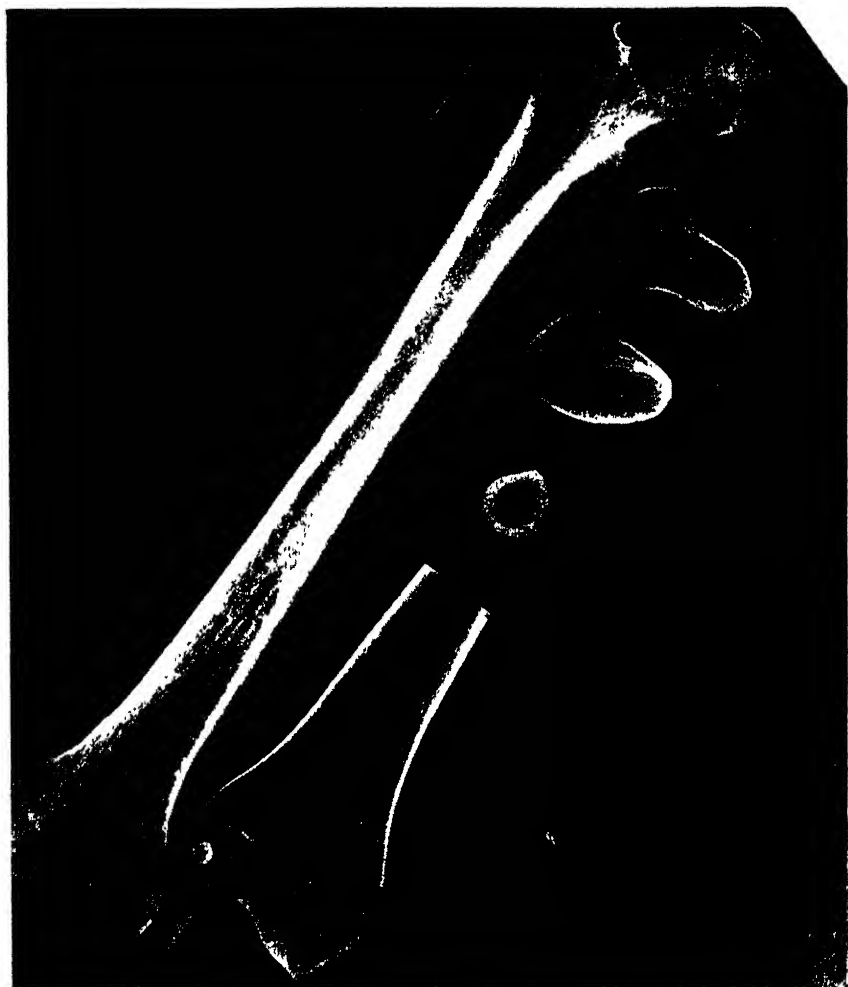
RADIOGRAPHIC APPEARANCES (NEGATIVE) OF A LONG BONE, AND OF SECTIONS SHEWING SPONGY BONE.
